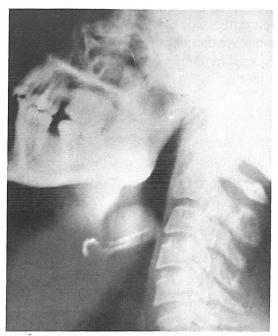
Lateral neck x-ray. Tumor seen in the inferior part of the oropharynx.
